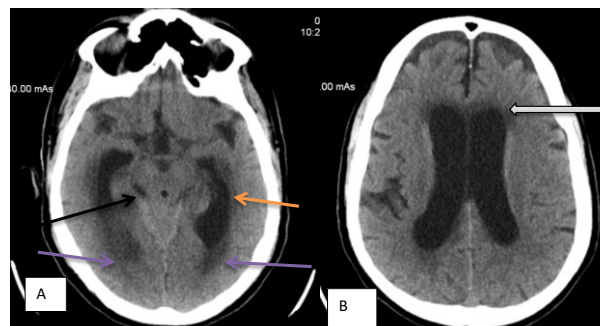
CT Scan cranian contrast: A. Superior vermian (Culmen) herniation, predominantly on the right (Black arrow-reduction of the quadrigeminal cistern). Acute internal hydrocephalus. (Orange arrow-increase in size of the ventricular temporal horns). Ventriculitis (mauve arrow accumulation of purulent secretions in the distal ventricular portion) B. Acute internal hydrocephalus Periventricular hypodensity (white arrow)
